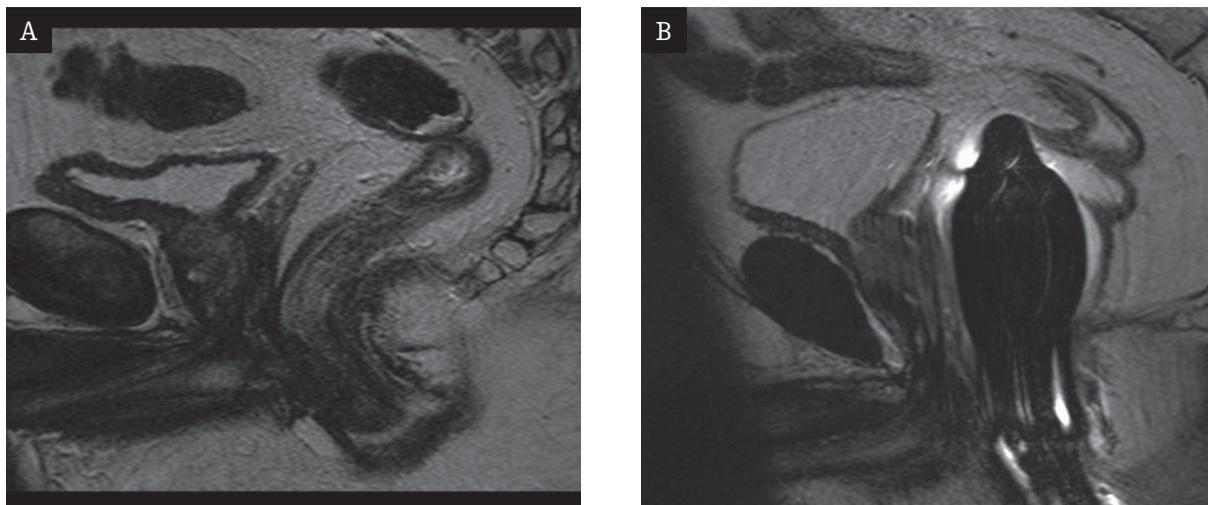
Influence of endorectal coil use. T2-weighted images in sagittal plane. A) image obtained from a surface coil, natural shape of the prostate gland; B) clearly visible endorectal coil; the gland is pressed, there are artifacts originating from the coil.
